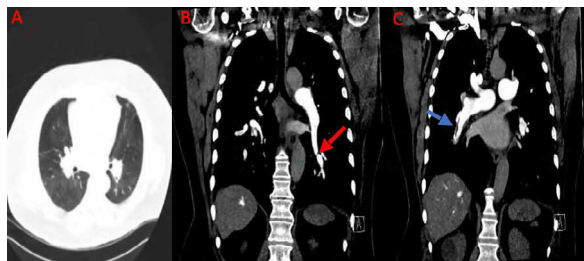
CT Pulmonary angiogram: axial image (A) showing mosaic perfusion pattern and coronal images (B and C) showing left lower lobe pulmonary artery segmental branch stenoses (red arrow) and clot lining proximal right lower lobe pulmonary artery (blue arrow)
